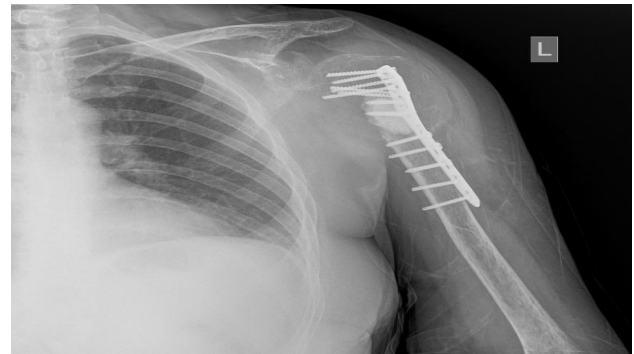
X-ray of left humerus of patient B preoperatively showing prior lateral plate and screw fixation of the proximal humerus extending from the head to the mid shaft. There is a large area of bone loss and destruction proximally at the level of the proximal meta-diaphysis corresponding to the tumor. Presence of cement of 3.6 cm in craniocaudal extent with overlying medial bone loss. No definite calcified matrix could be identified.
